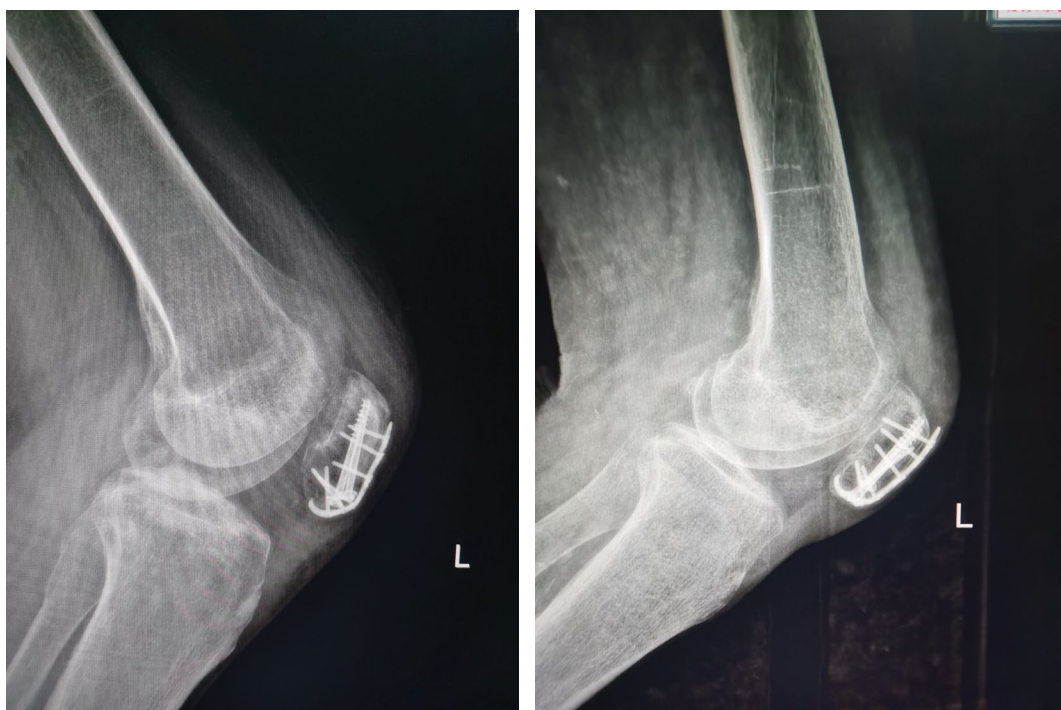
Postoperative radiograph of double button plate fixation (4 months).
